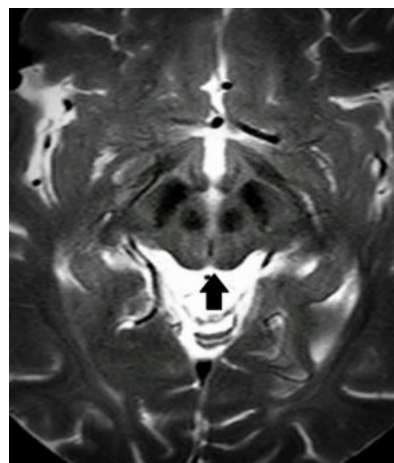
Image showing MRI brain - Face of giant panda sign
